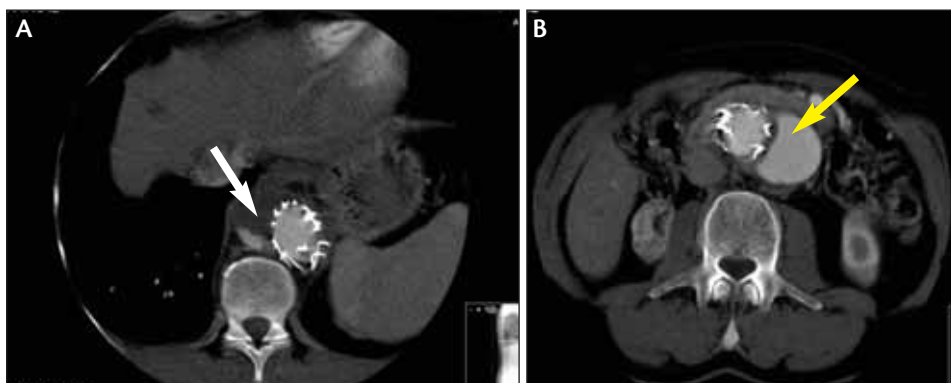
A postprocedure CT scan shows partial thrombosis of the false lumen in the thorax, with some residual perfusion (white arrow) (A) and persistent perfusion of the false lumen in the abdomen (yellow arrow) (B).
